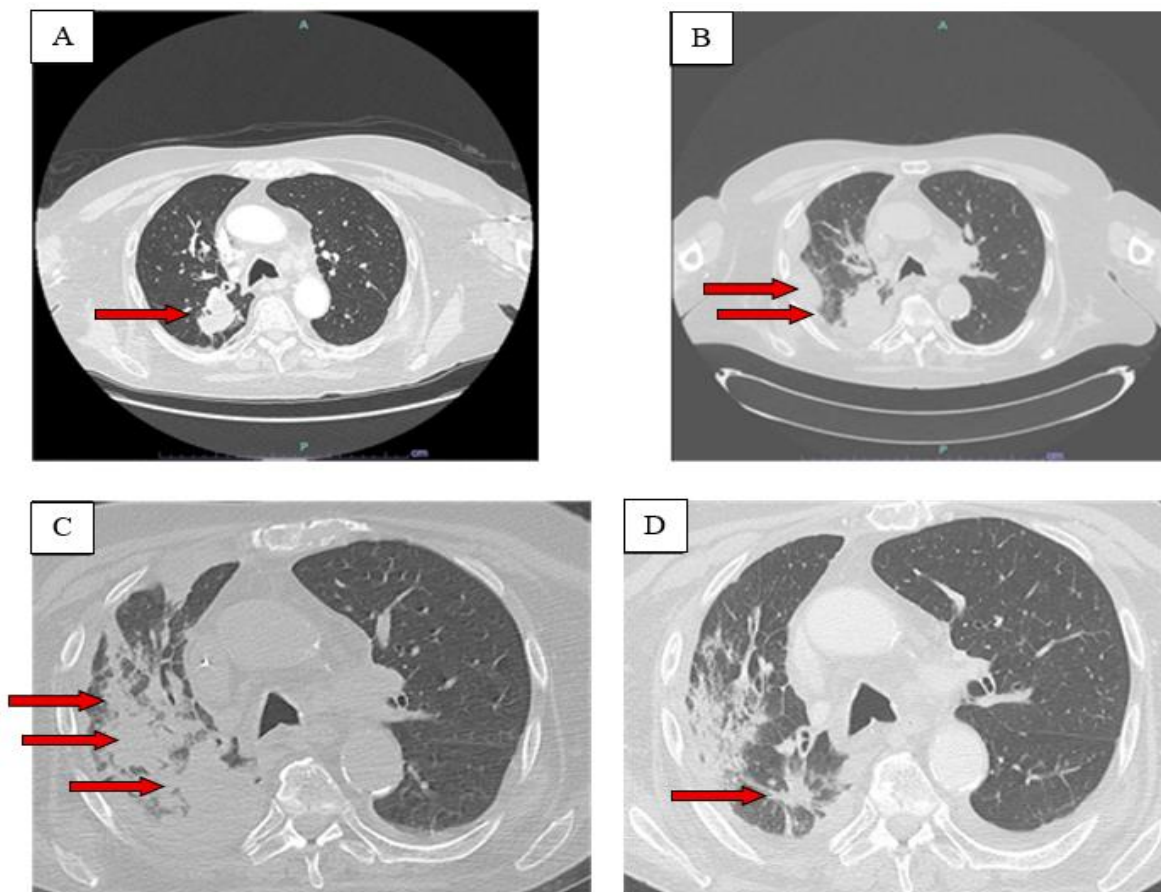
Chest CT images from January 2024 (A) and in May 2024 (B), three months after starting chemotherapy; (C) shows CT images of the chest before (June 2024) and after (August 2024 (D)) starting treatment with capmatinib. The largest diameter of the right lung lesion is 43.12 mm in A, 45.02 mm in B, 47.09 in C, and 15.26 in D. Figure B shows the right-sided pleural effusion in addition to the lung lesion. Figure C, shows a diffuse confluent parenchymal thickening in the right lung that could have been due to COVID-19, cancer progression, or both.
